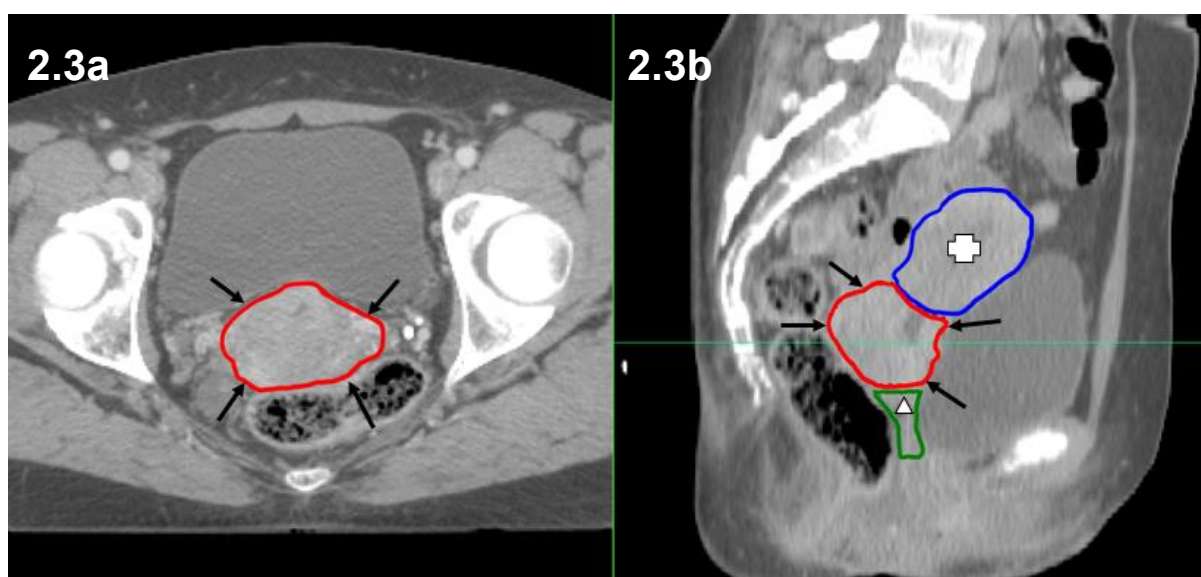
Transverse (a) and sagittal (b) CT of the cervix and gross tumour outlined as a single structure (arrowed in a and b). The uterine corpus (cross) and vagina (triangle) outlines can also be seen on the sagittal image (b).
